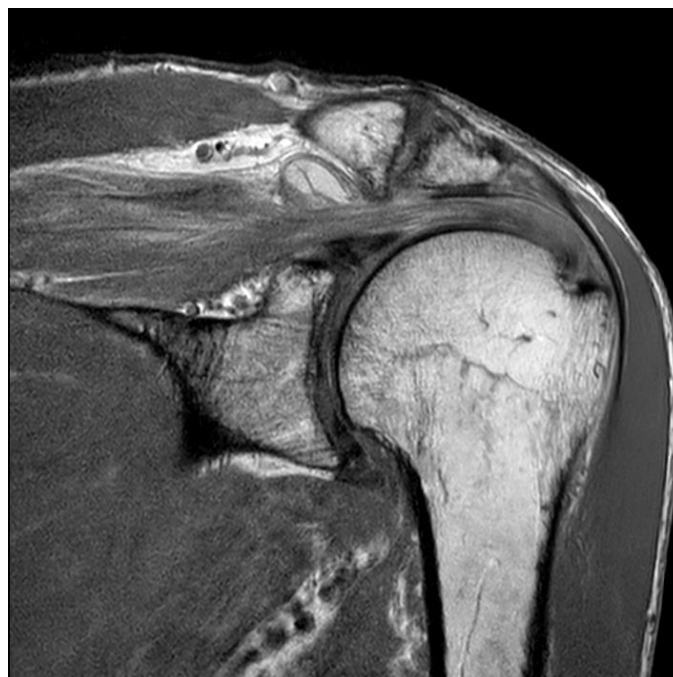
Pre-treatment shoulder MRI
